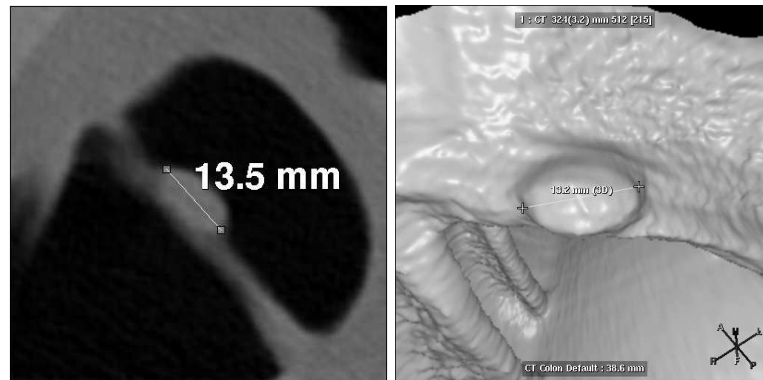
Manual size measurement in CT Colonography using digital calipers. The operator selects two points on each side of the polyp. The distance between the points is used as a measure for polyp size. The size is either measured in 2D cross sectional views (a) or in 3D isosurface renderings (b).
